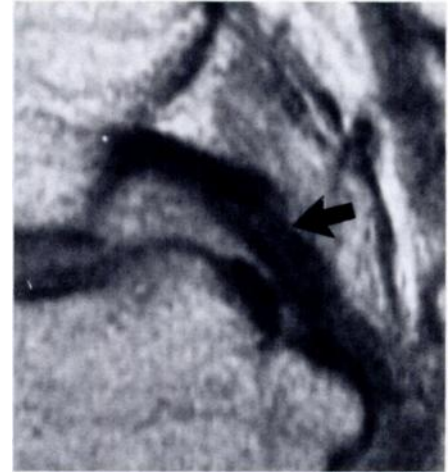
MR images of a 37-year-old man with knee pain and anteroposterior instability following a basketball injury. (a) Sagittal T1-weighted MR image shows possible distortion of the ligament (arrow) and higher signal intensity in the distal portion of the ligament. (b) Sagittal T2-weighted image shows an intact PCL. Clinical examination revealed no evidence of PCL tear, and the patient is doing well at 6-month follow-up.
